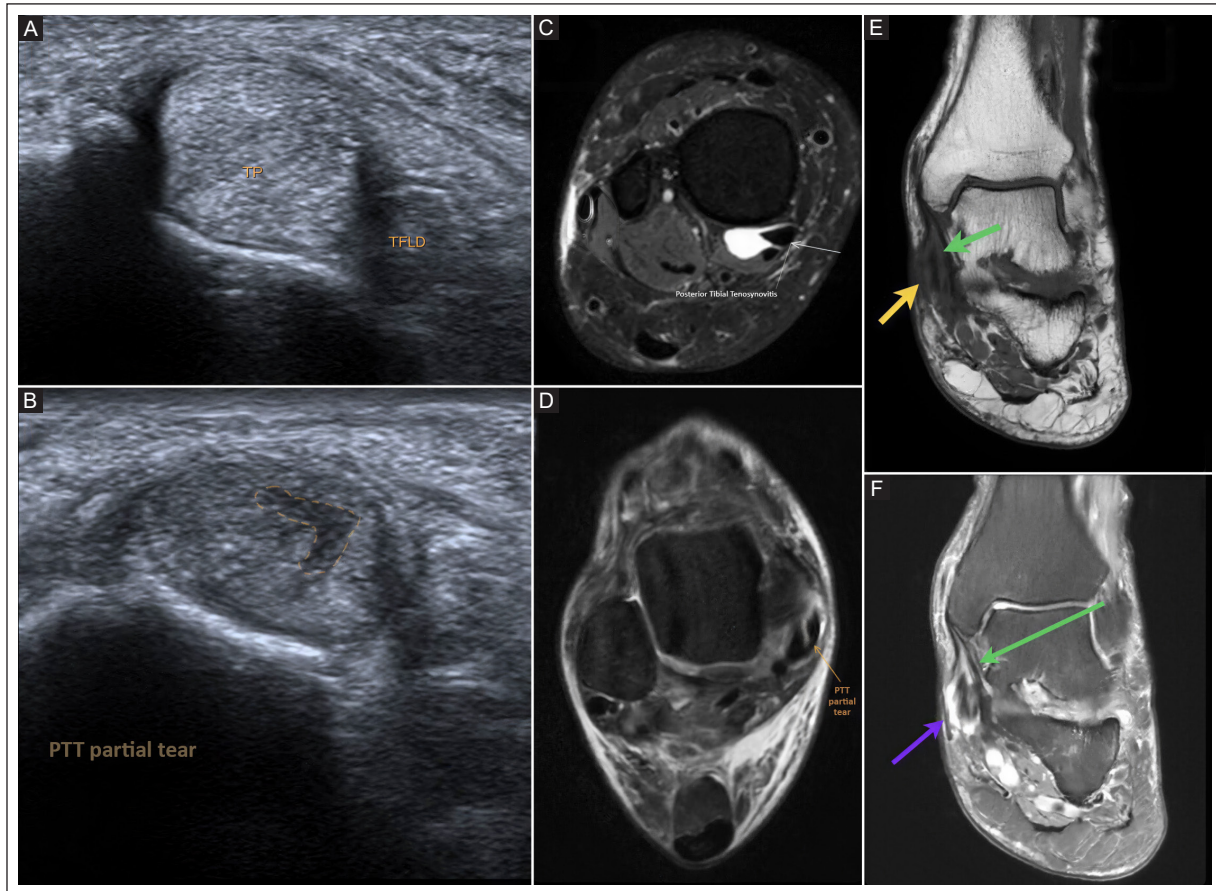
A: thickening of the posterior tibial tendon consistent with tendinosis. B: linear hypoechoic defect within the PTT, consistent with a partial tear. C: axial fluid-sensitive MRI sequence demonstrating tenosynovitis. D: axial fluid-sensitive MRI sequence showing a linear intratendinous defect consistent with a partial tear. E-F: coronal MRI T1-weighted and fluid-sensitive sequences, respectively. Yellow and purple arrows indicate disruption of the fibrillar pattern of the posterior tibial tendon, consistent with a partial tear. On the fluid-sensitive MRI sequence, associated tenosynovitis is also observed. The green arrow highlights the deltoid ligament, which appears thickened, consistent with a sprain.
